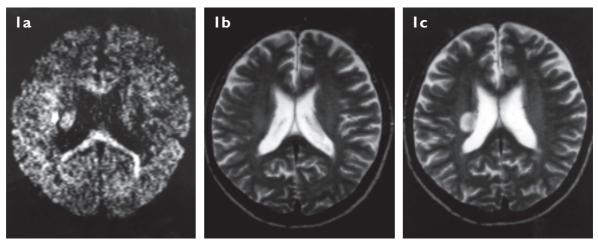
I (a) DW scan at five hours post-ictus demonstrates definite small hyperintensity (arrow) in the right corona radiata (scored 3), corresponding to patient's acute left sided weakness. (b) T2-weighted scan at the same level shows no discernible infarct, even in retrospect. (c) T2-weighted scan on day 6 reveals interval appearance of lacunar infarct.
